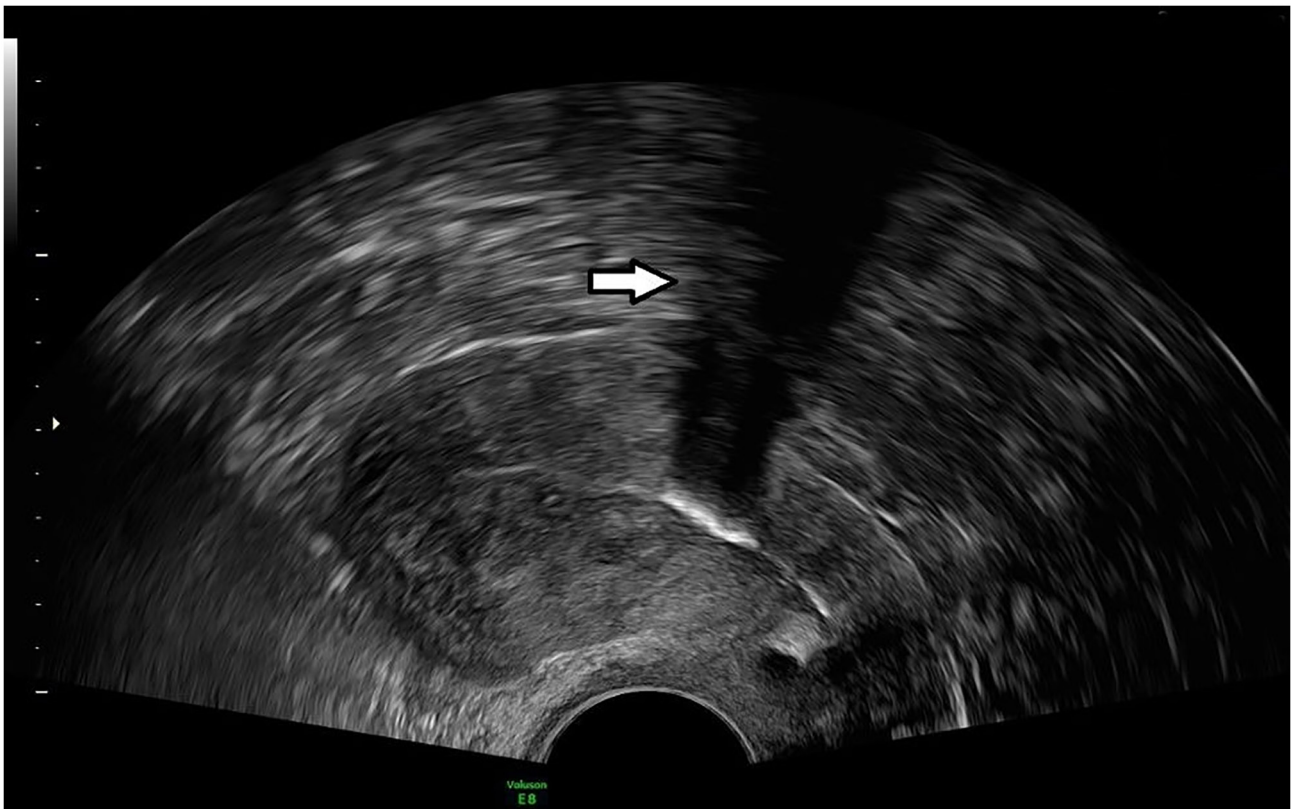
Transvaginal ultrasound image. The white arrow indicates the hyperechoic linear area with posterior acoustic shadowing.
